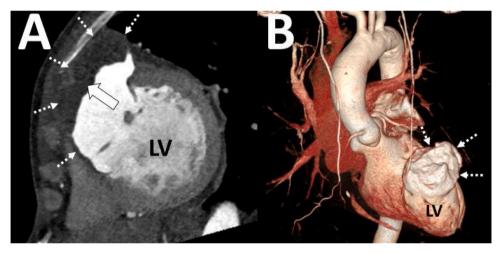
A 69-year-old man was referred for CCTA to plan percutaneous coronary interventions (PCI) of left anterior descending artery occlusion. Short axis view (A) and 3D volume rendering technique image (B) CCTA reveals left ventricular aneurysm (dashed arrows) with mural thrombus (arrow). (CCTA : Cardiac computed tomography angiography, LV : Left ventricle).
